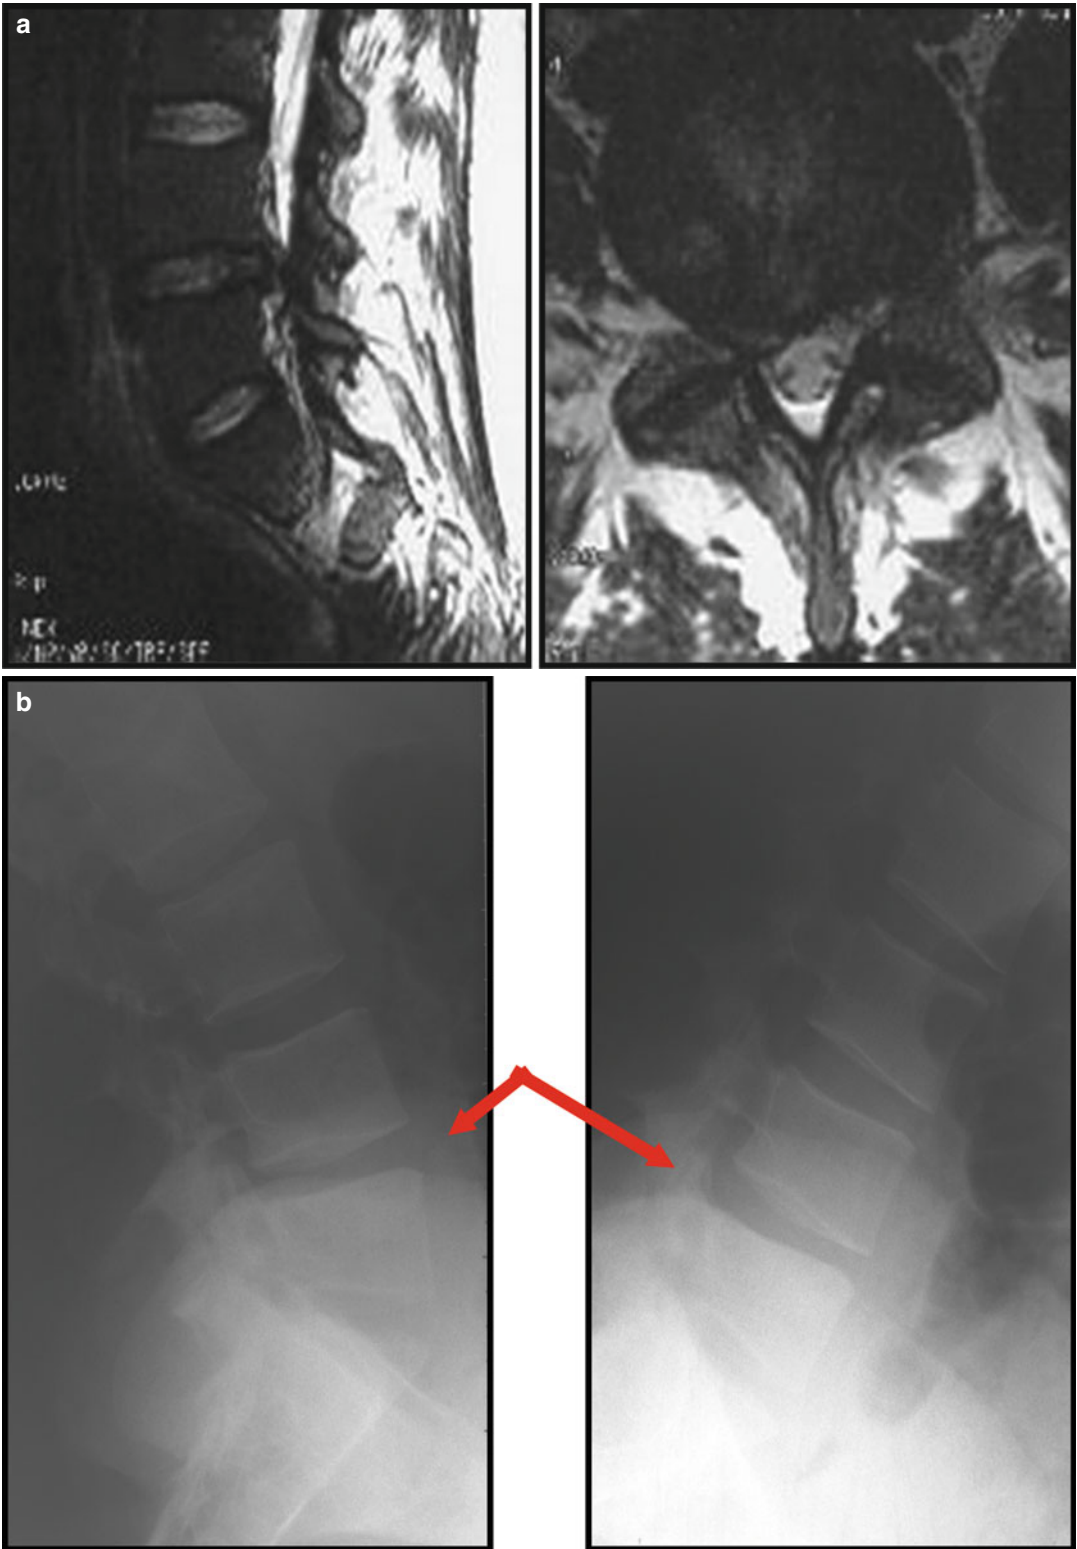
(a) Preoperative MRI for patient no. 1; *left* lateral disk herniation at L4–L5. (b) Dynamic flexion-extension X-rays at 64 months postoperative for patient no. 1; normal spinal mobility and preserved disk height. *arrows* operating level
